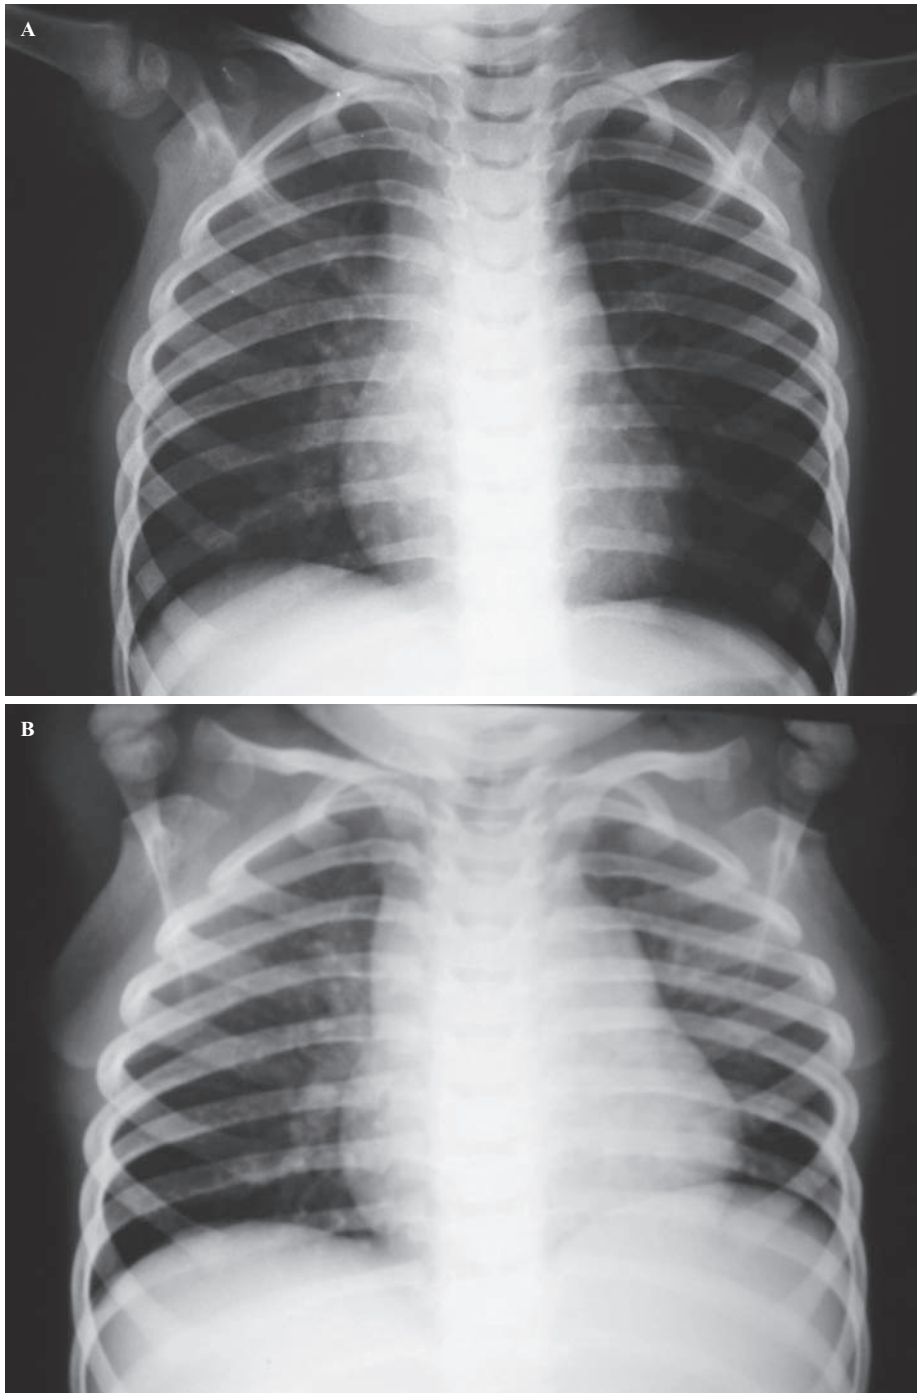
Chest radiographies in the two-year-old girl: (A) hyperinflation of the whole left lung at admission to the hospital; and (B) there were no signs of hyperinflation six months following bronchopexy. Hypoplasia of the left lung with elevation of the ipsilateral hemidiaphragm was noticed.
